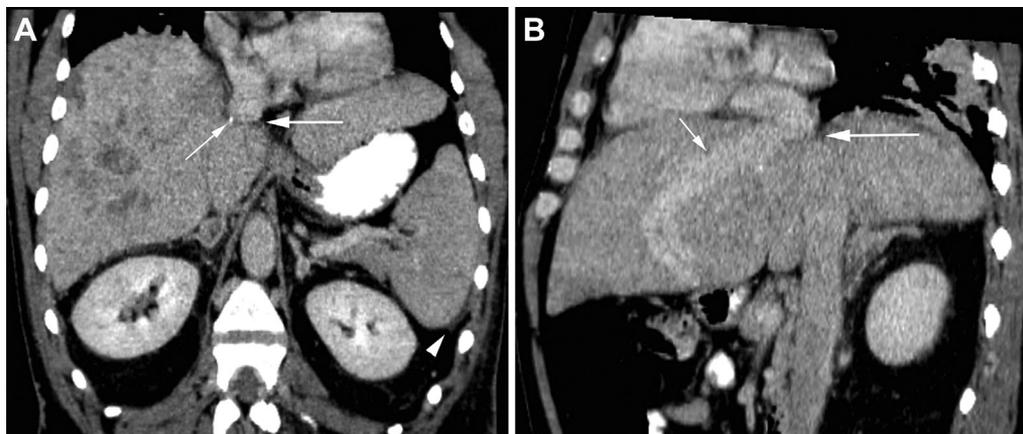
(A) Oblique coronal portal venous phase CT image demonstrates short, focal web-like obstruction of the intrahepatic IVC (large arrow) measuring less than 1 cm in length consistent with membranous occlusion. A small punctate focus of calcification suggests a component of chronicity to this finding (thin arrow). The hepatic parenchyma is mildly heterogeneous, and there is a trace amount of ascites at the hepatic and splenic tips (arrowhead). (B) Oblique sagittal CT image in the same phase shows the left hepatic vein (thin arrow) draining into the IVC above the level of the occlusion (large arrow). CT, computed tomography; IVC, inferior vena cava.
